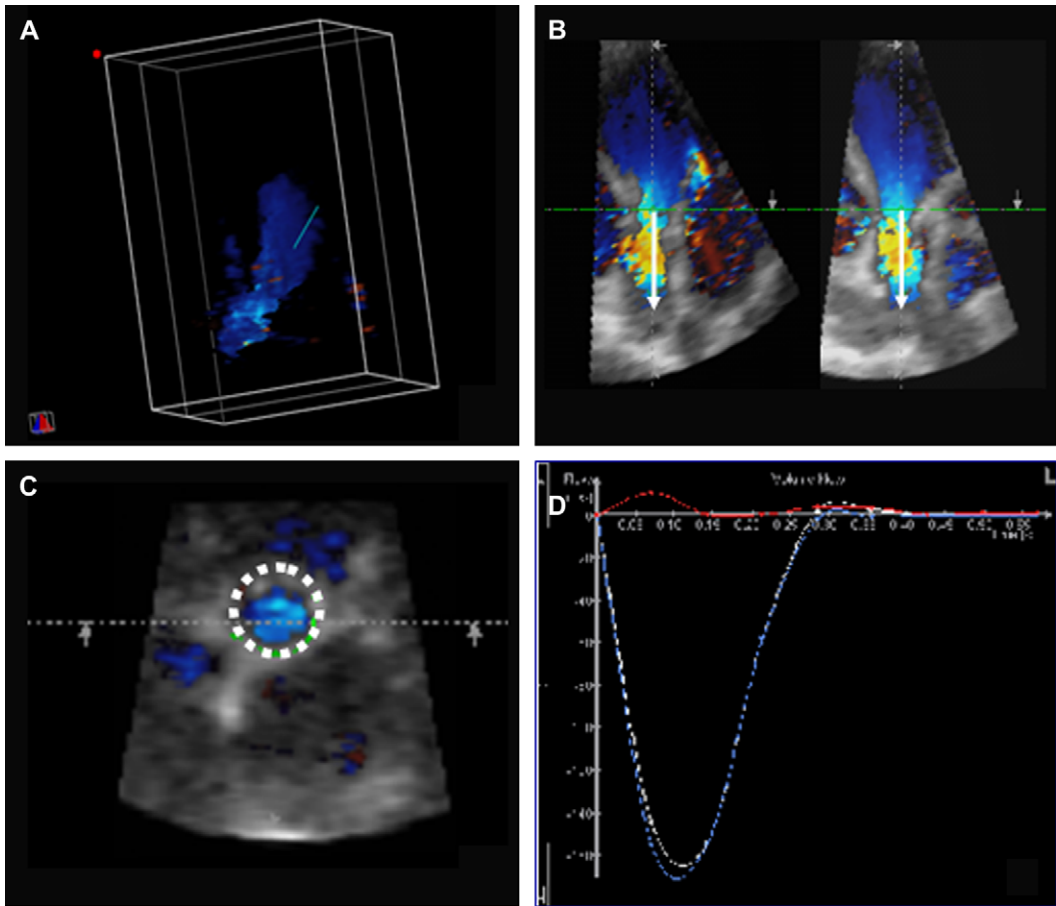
Cardiac output estimation using off-line analysis software to quantitate flow rate (TomTec Imaging Systems, Unterschleißheim, Germany). A 3D color Doppler volume data set (A) subsequently is displayed in two orthogonal planes (B). Arrows (white) indicate the direction of flow, which automatically is aligned perpendicularly along a curved surface. In a third multiplanar view, a circular region of interest is drawn to calculate flow rate (C and D).
